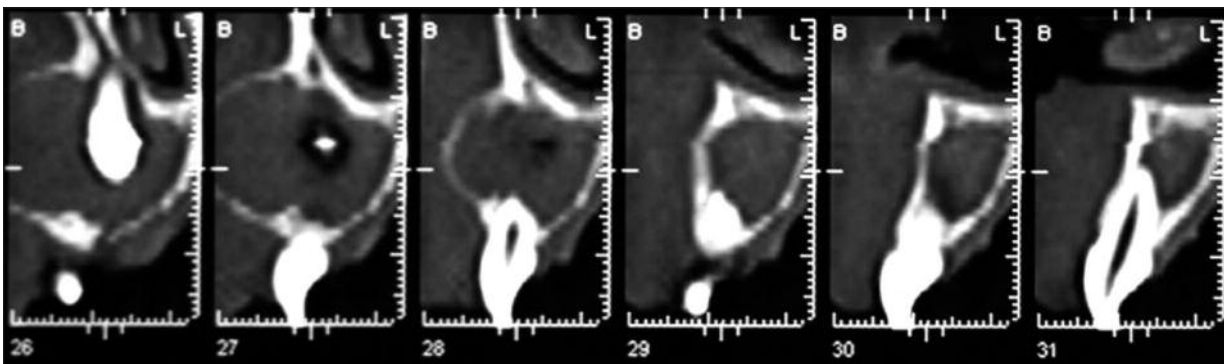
Pre-Operatory CT examination.
